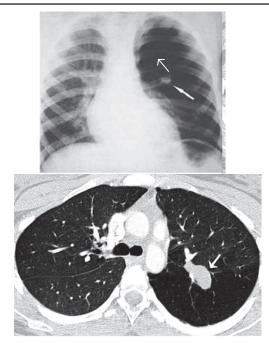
X-ray chest PA - Left bronchial atresia (arrow head) bronchocele as small ovoid parahilar mass.
